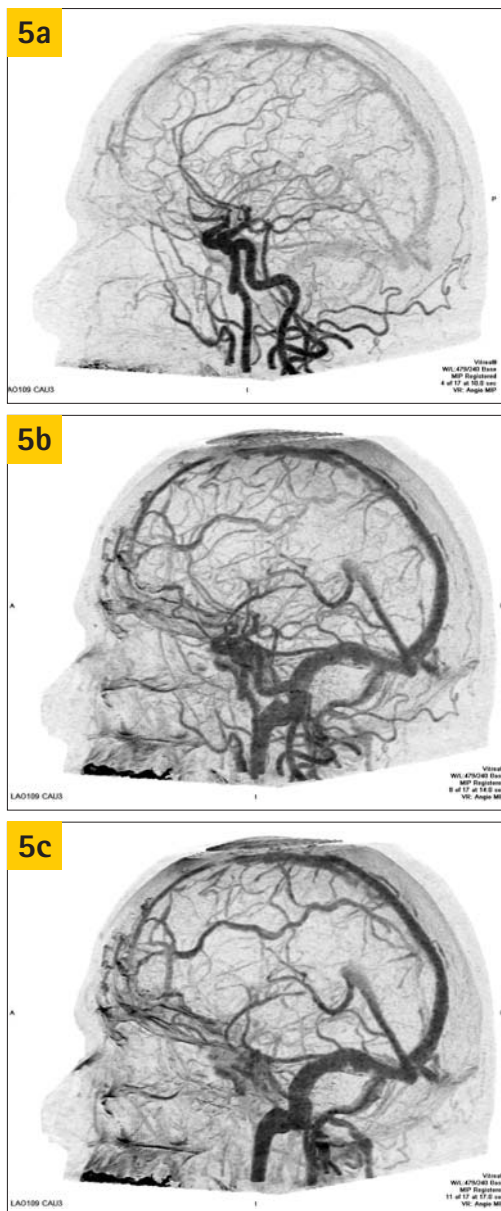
Four-dimensional CT angiography of intracranial arteries. From top to bottom: early arterial, arteriovenous and venous phases of contrast passage.
